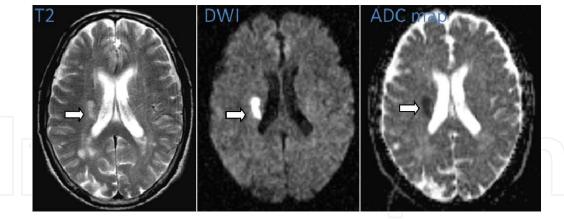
Hyperintense lesion at the right corona radiata with increased signal intensity on DWI and decreased signal intensity on ADC map due to acute infarction.
